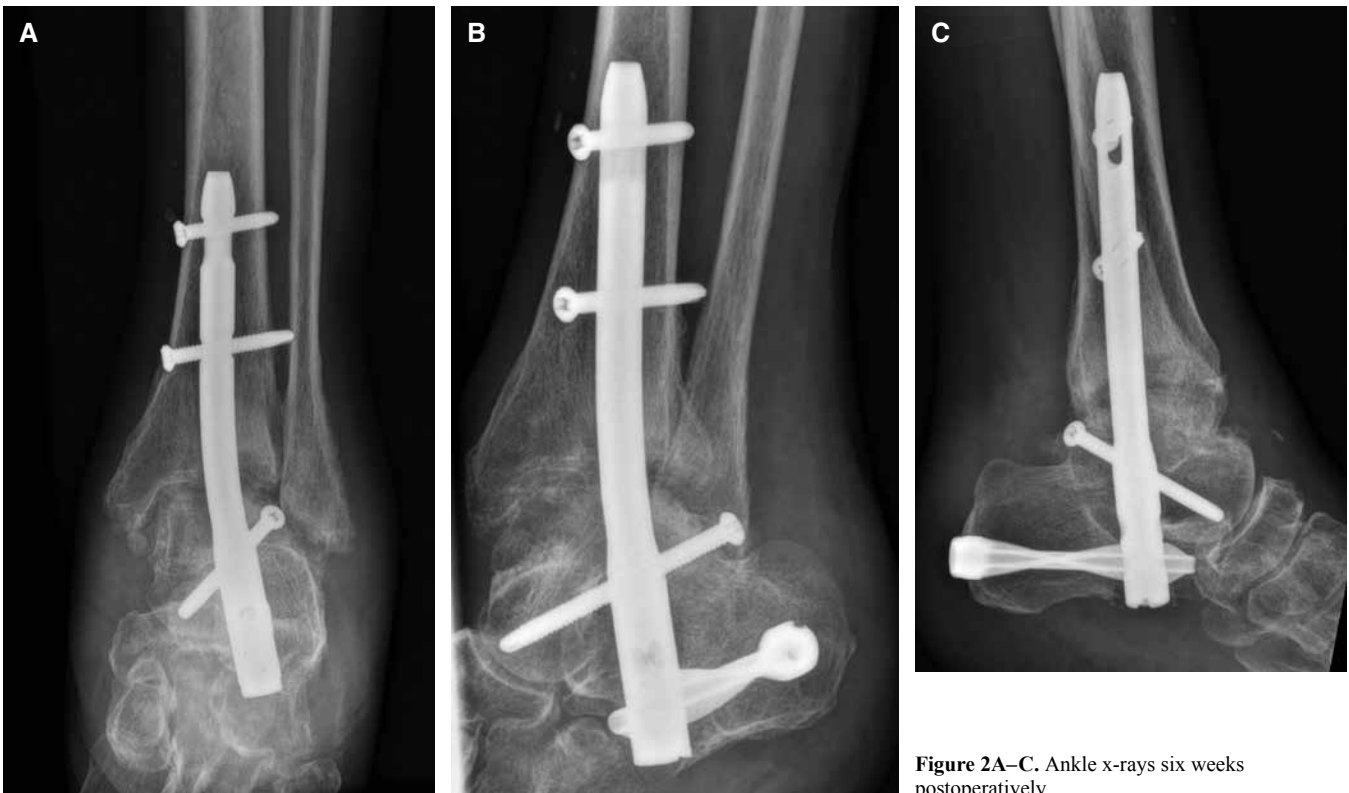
Ankle x-rays six weeks postoperatively.
